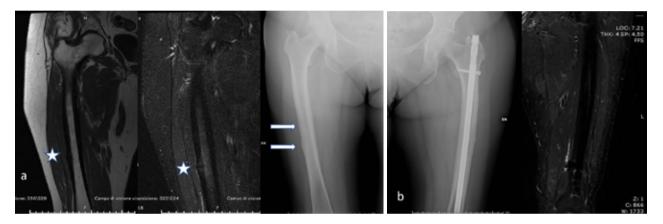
(a) Right femur findings at MRI and Xray images: black line, bone edema and periosteum reaction (*) and cortical bump (\rightarrow) . (b) Left femur follow up images show healing.
